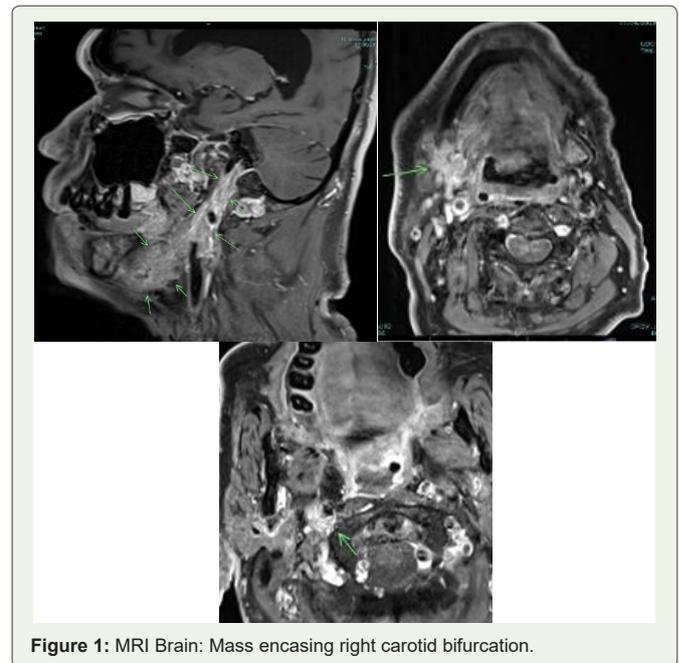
MRI Brain: Mass encasing right carotid bifurcation.
